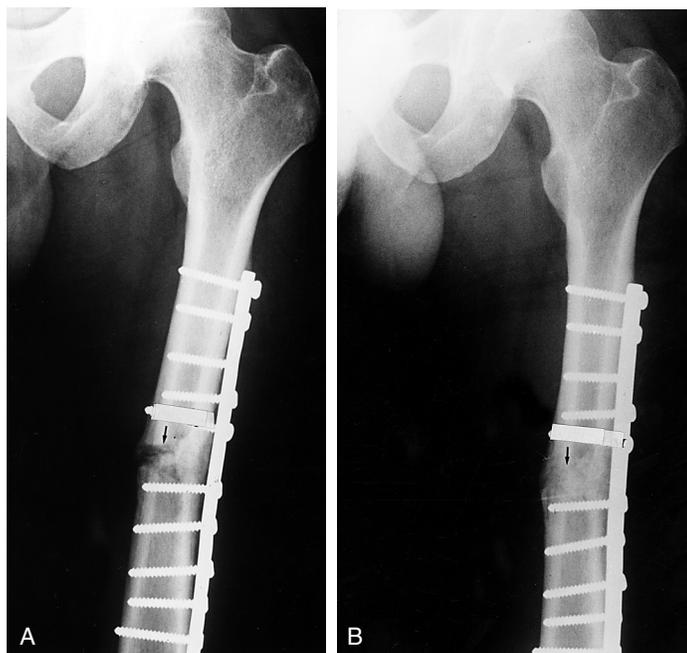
(A) Radiograph of the right femur of a 32-year-old man showing nonunited fracture 9 months after the initial open reduction and internal fixation. (B) Radiograph of the same femur taken 3 months after treatment with 6000 shock wave impulses showing bony union.
